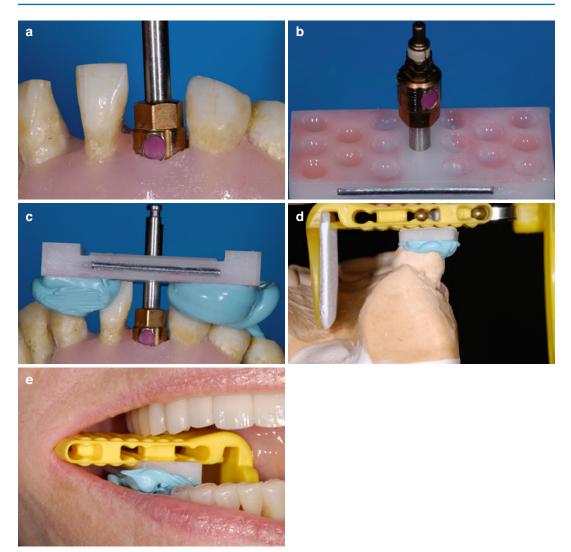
Fabrication and clinical application of the X-ray paralleling device are critical in helping operators obtain diagnostic radiographs for implant assessment. (a) Access to implant fixture obtained intraorally or from implant master cast; implant placement driver is attached to the fixture. (b) Connect the paralleling PIXRL device to shank of implant placement driver; adhesive is applied on undersurface of the jig. (c) Orient PIXRL jig assembly to
